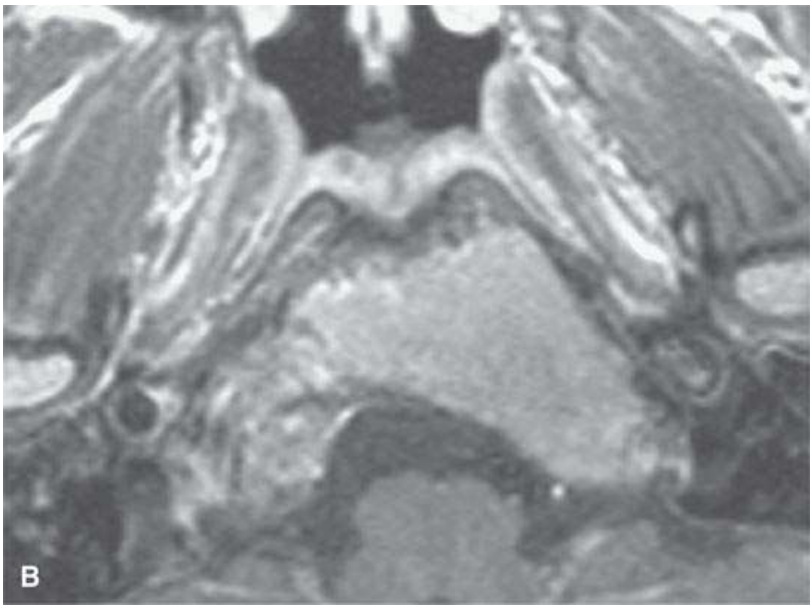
A–C: Magnetic resonance imaging of a chordoma of the lower clivus, with the “watery” nature of the tumor cells and stroma much more apparent by the way of its signal intensity approaching and matching that of cerebrospinal fluid in some areas on the T2-weighted image in (cC) than on the non–contrast-enhanced (aA) and contrast-enhanced (bB) T1-weighted images.
